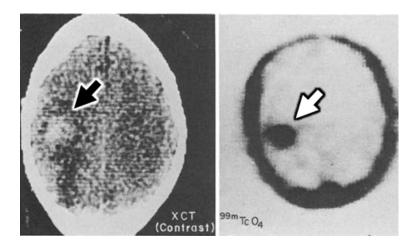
Brain metastasis. 52-year-old male with intracranial metastatic bronchogenic carcinoma. Due to altered blood brain barrier mechanics, a right cerebral hemisphere metastasis is identified on the post-contrast CT imaging (closed arrow) with corresponding radiopharmaceutical uptake on SPECT (open arrow). Published with permission granted by RSNA[®], originally published as Figure 8 in: Kuhl, DH, Edwards, RQ, Ricci, AR, et al. The mark IV system for radionuclide computed tomography of the brain. *Radiology*. 1976;121:405-413.
